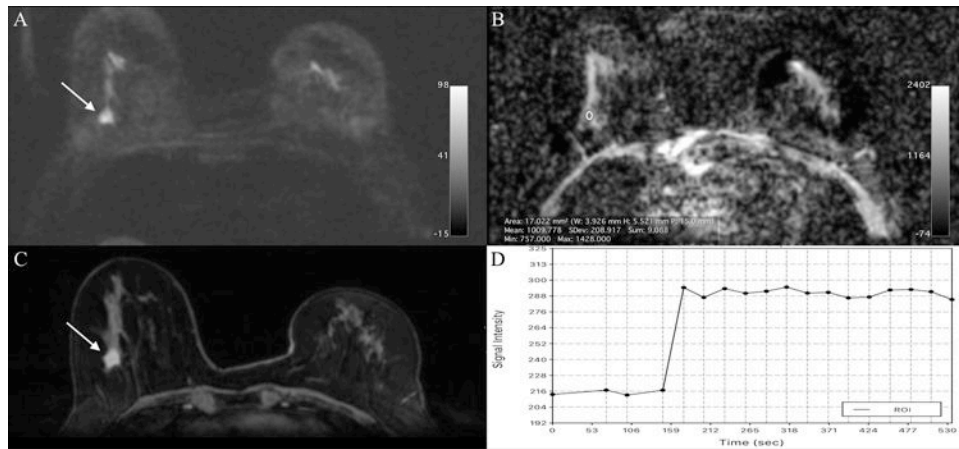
Invasive ductal carcinoma (IDC) grade 1 laterally in the right breast in a 63-year-old woman: (A) On DWI in the high b-value images there are restricted diffusivity (arrow) and (B) decreased ADC values ($1.009 \times 10^{-3} \text{ mm}^2/\text{s}$) evident; thus DWI findings were classified as positive for malignancy. On DCE-MRI there is a 13mm (C) irregular shaped and partly spiculated mass with (D) an initial fast heterogeneous contrast enhancement followed by a plateau; thus DCE-MRI findings were classified as BI-RADS 5. DWI accurately detected this breast cancer.
